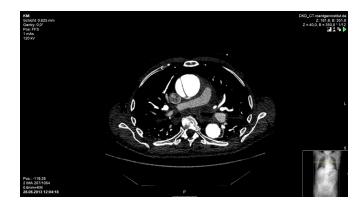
Preoperative, transverse CT-scan of the dissected aorta ascendens.
